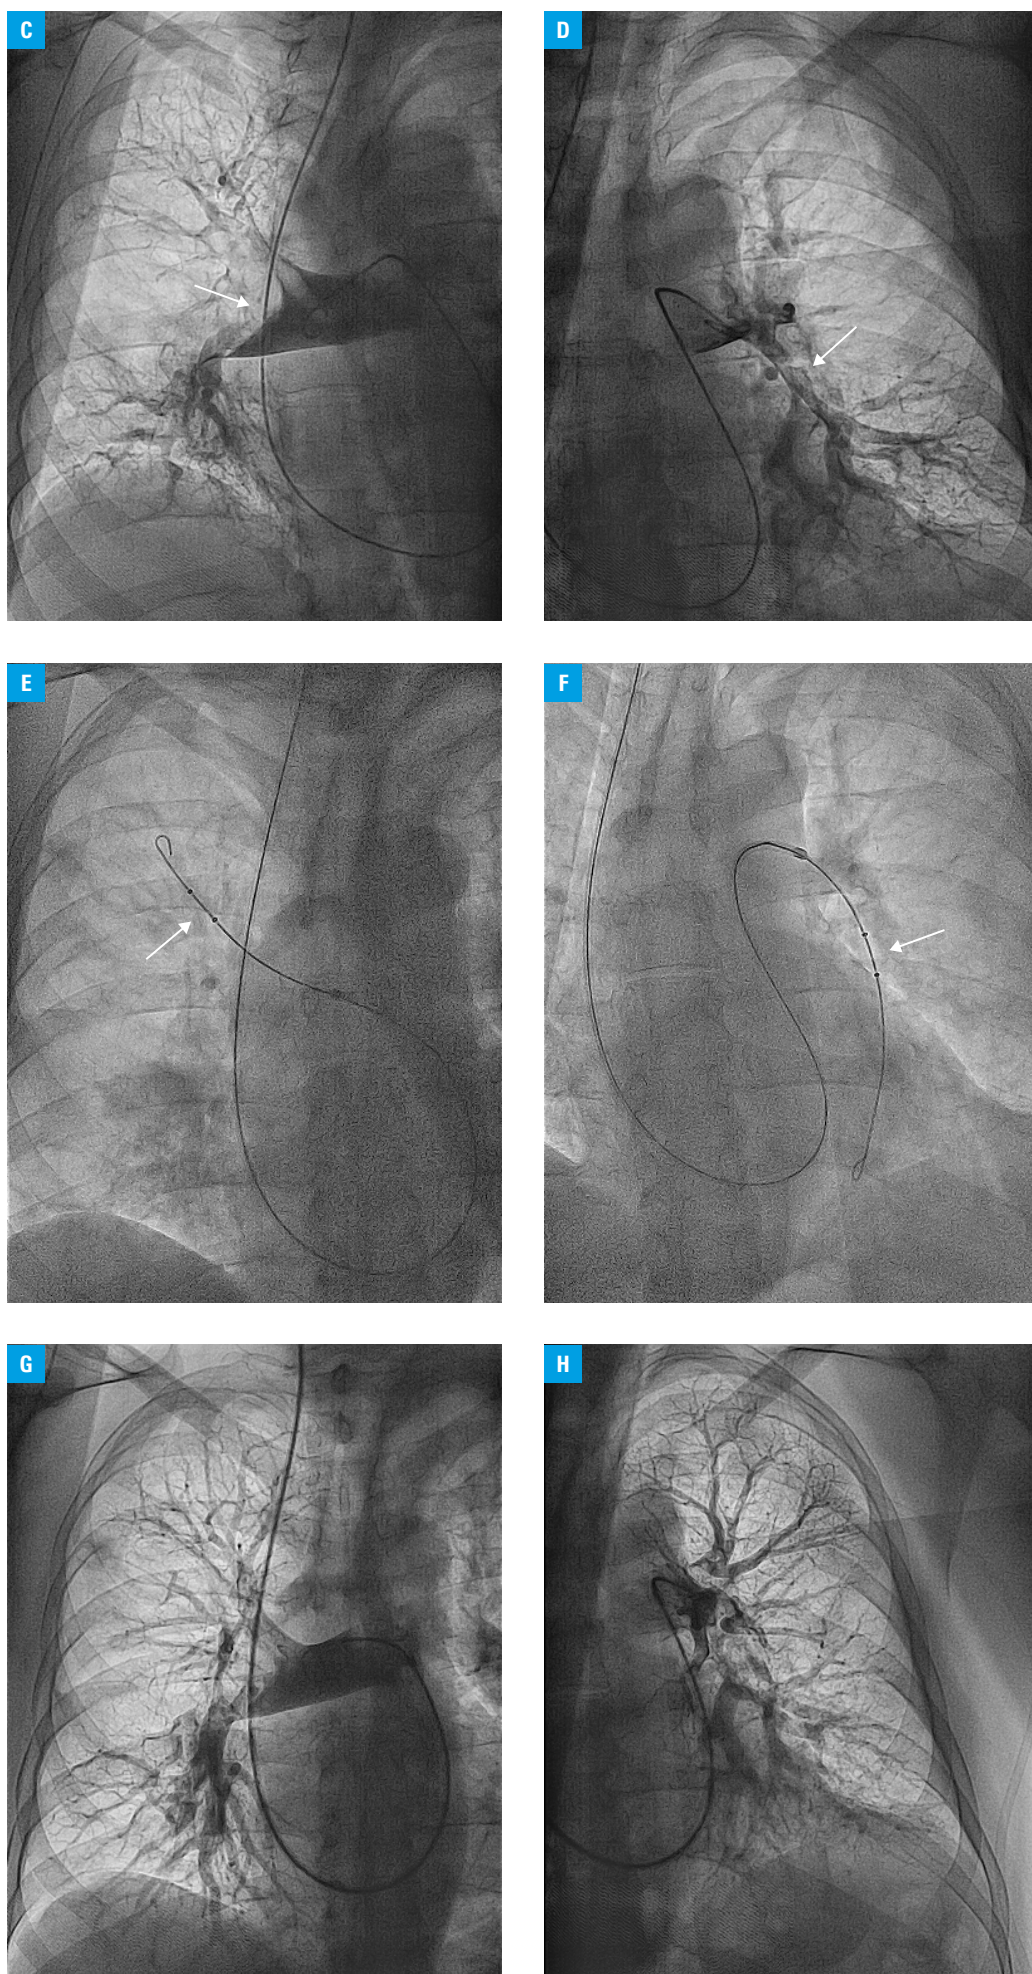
Computed tomography (CT) pulmonary angiography and pulmonary artery angiography in a patient with COVID-19 pneumonia and acute pulmonary embolism; A – coronal reconstruction from the initial CT demonstrating COVID-19 pneumonia; B – axial image from CT pulmonary angiography showing bilateral pulmonary embolism (white arrows) and a large saddle thrombus (blue arrow)
